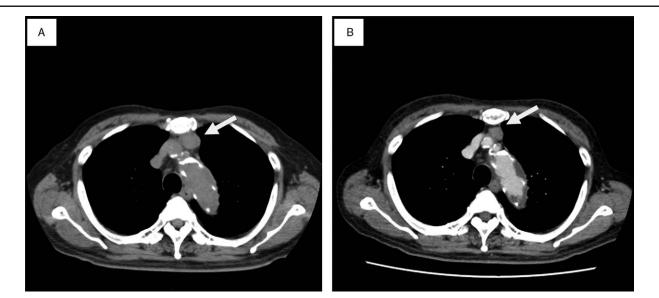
Chest computed tomography scans showed a mass in anterior mediastinum (arrows) (A; plain, B; enhanced). It had well-defined borders with little contrast effect.
